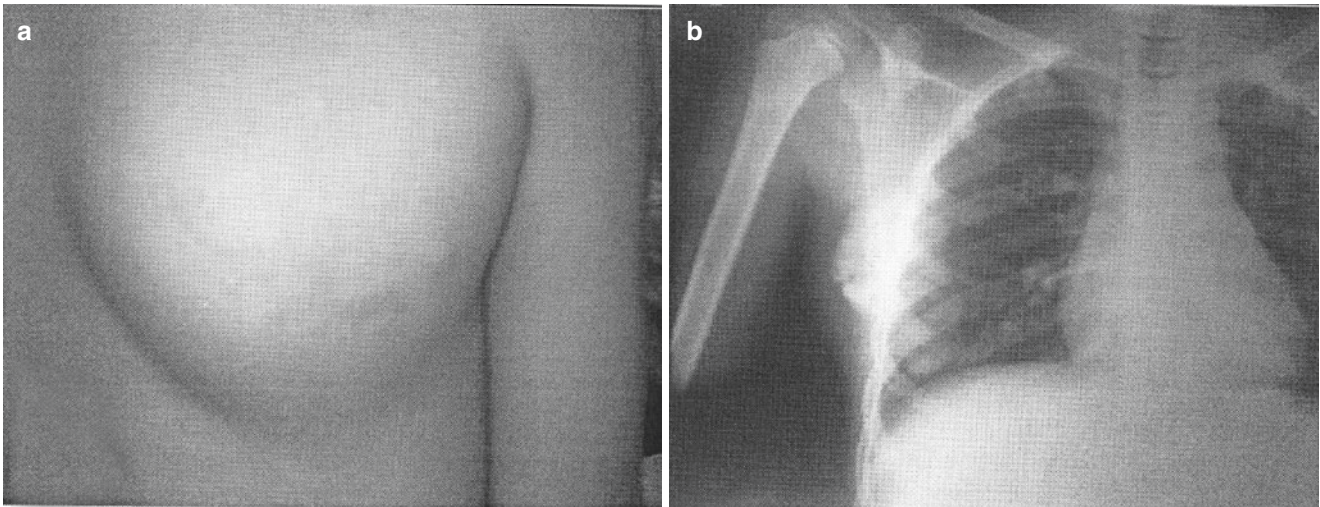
Tumoral calcinosis of the chest wall. (a) Clinical picture. (b) Plain chest radiograph
